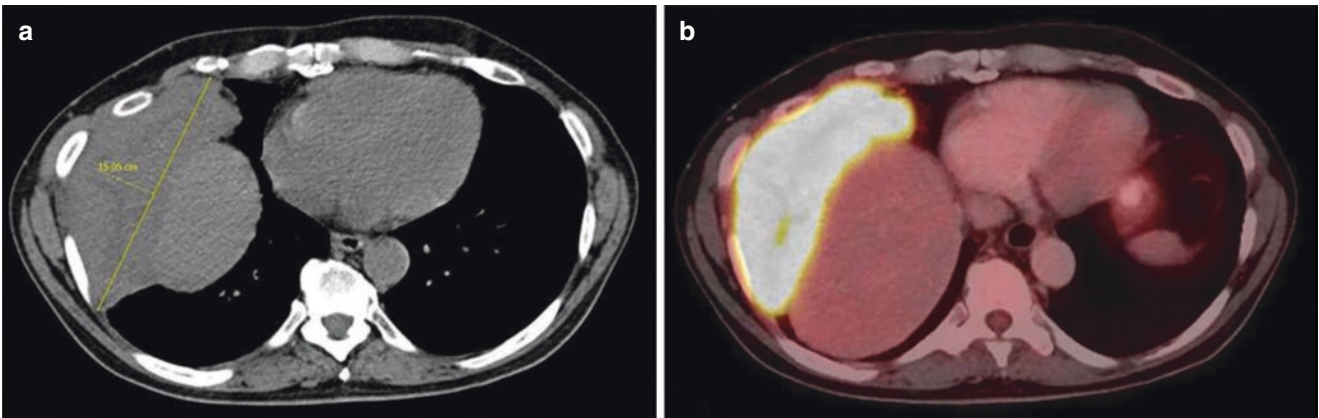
Imaging study of the thorax. CT scan (a, axial plane; c, coronal plane) shows a 15 × 6 cm poorly circumscribed right lower lung mass protruding into the eighth and ninth intercostal spaces. (b, axial plane; d, coronal plane) PET scan shows a 15 cm right inferior lung mass and a 6 cm right superior paramediastinal mass with a high FDG
